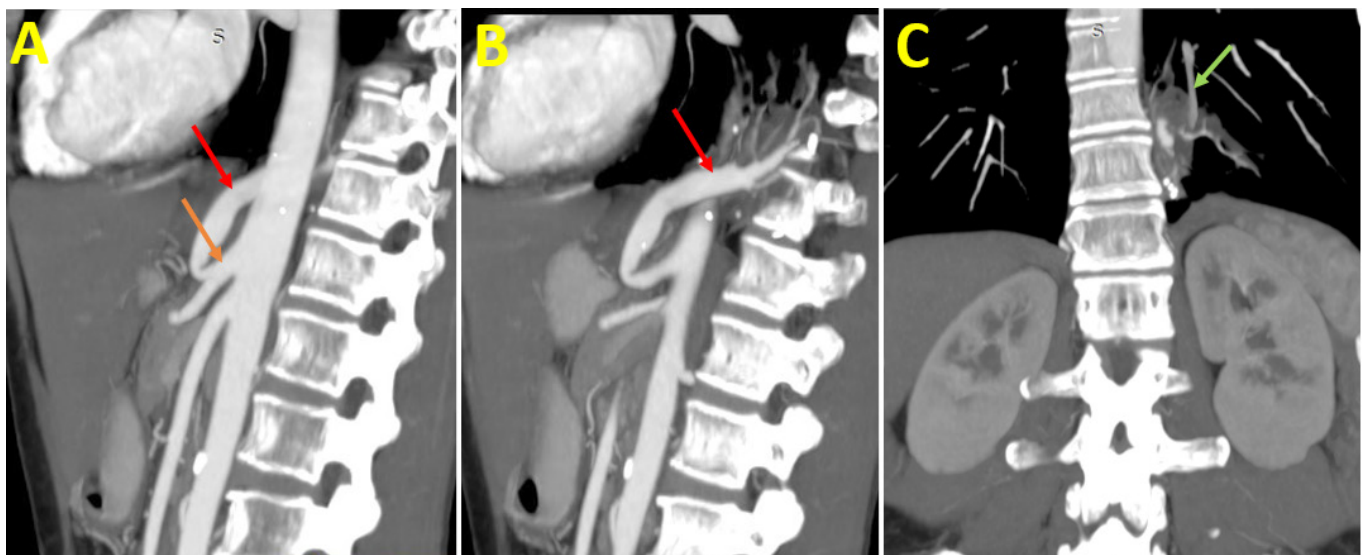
Contrast-enhanced CT scan arterial phase MIP images. A and B: Sagittal reformatted images (arterial phase) show an apparent artery (red arrow) supplying the pulmonary lesion arising from the celiac artery (orange arrow). C: Coronal reformatted MIP image (venous phase) shows the venous drainage (green arrow) of this pulmonary lesion to the left inferior pulmonary vein.
